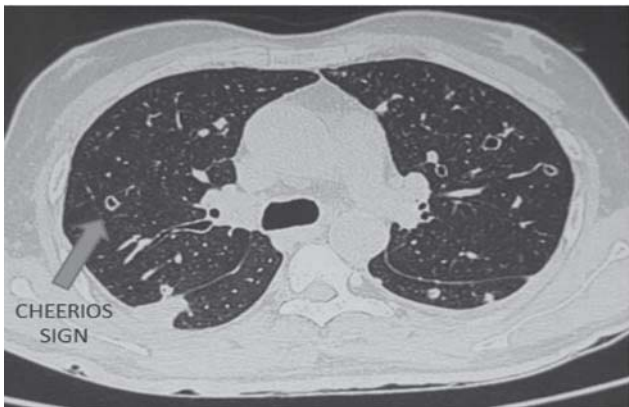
Computed tomographic of the thorax (lung window transverse section) showing "cheerios sign" (arrow).
